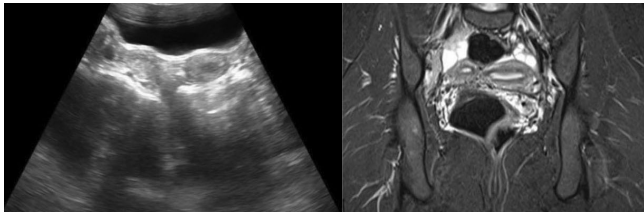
(A): Axial ultrasound image demonstrates two separate endometrial cavities in a case of bicornuate uterus. Figure 2(B): Coronal FLAIR MRI reveals the two cavities in more elaborate detail.
